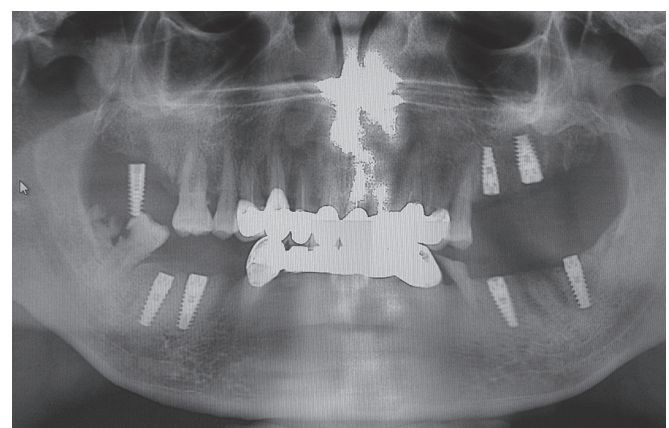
Preoperative orthopantomogram showing displaced implant
